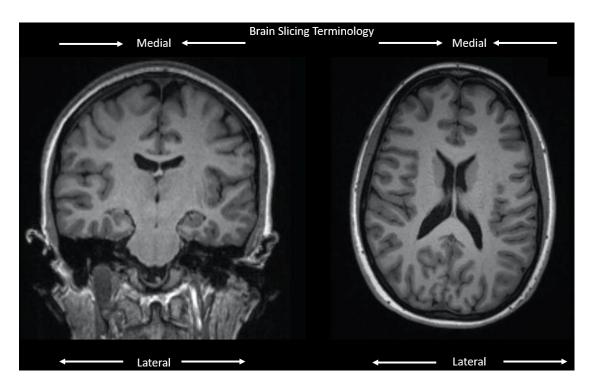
Coronal View of the Brain (Left) and Axial View of the Brain (Right). Both Images Include Directional Terminology. Source: Gateway MRI Center, Joint School of Nanoscience and Nanoengineering, The University of North Carolina at Greensboro.
